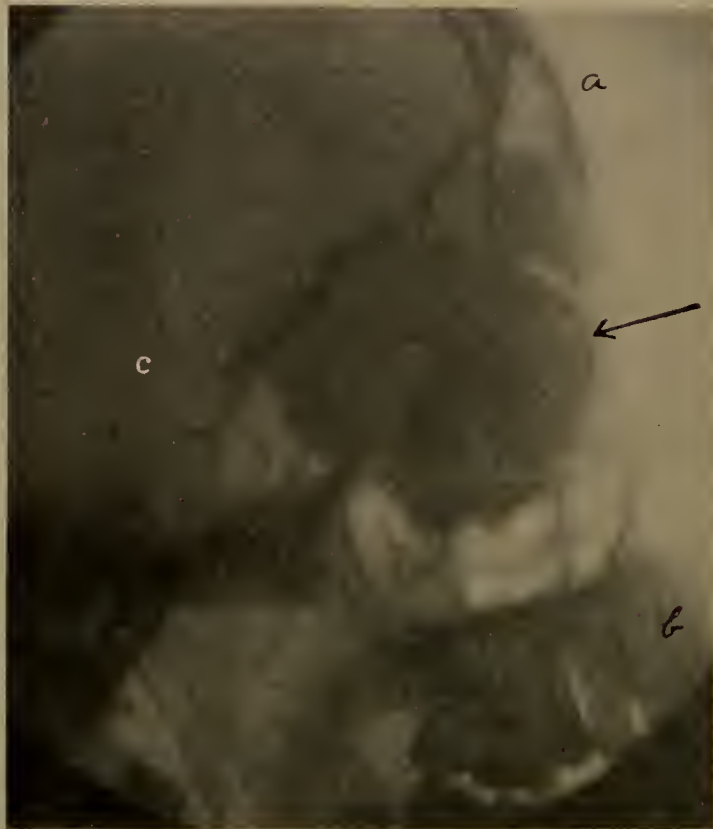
Osteoma of the left orbital space. (See Fig. 134.) X-ray shows the solid bony tumor. Arrow points to tumor. *a*, Frontal sinus; *b*, incisor teeth; *c*, sella turcica.
